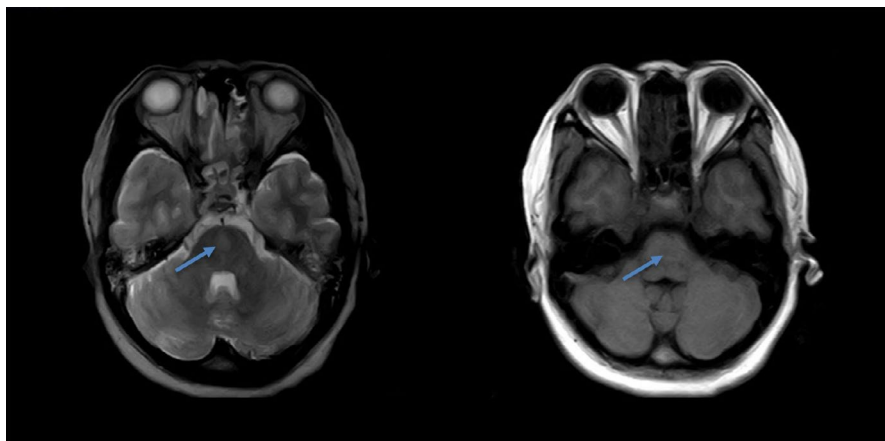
Features suggestive of ODS seen in the MRI of the brain
